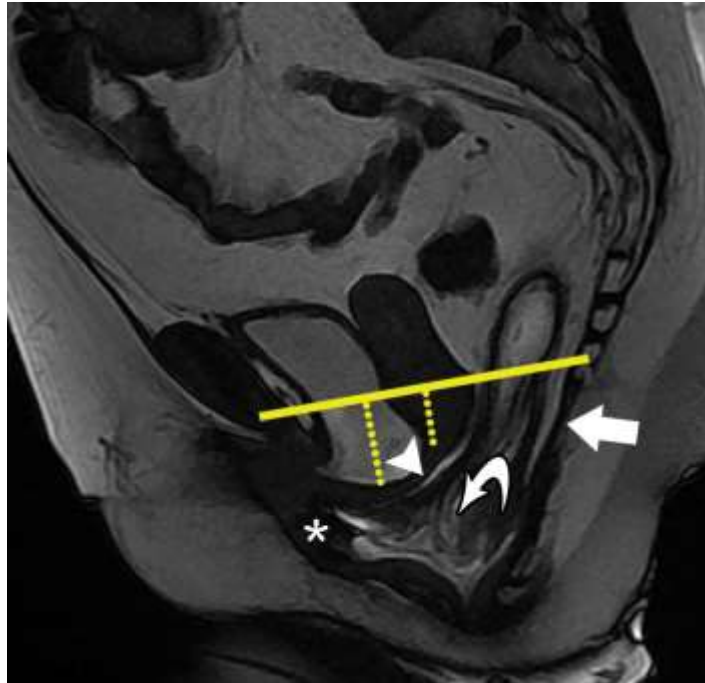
Rectal intussusception in a 48-year-old woman with suspected obstructed defecation. Midsagittal FIESTA MR image obtained during defecation shows intrarectal intussusception of the rectal wall (curved arrow). A large anterior rectocele (*) and pronounced caudal angulation of the levator plate (straight arrow) also are depicted. In the anterior and middle compartments, a moderate cystocele (long dotted line) and mild uterine prolapse (short dotted line) can be seen along with a peritoneocele (arrowhead), a lamella of mesenteric fat extending into the rectovaginal space alongside the upper third of the vagina. The detection of rectal intussusception in this patient altered surgical planning, resulting in the use of a transabdominal approach instead of a transperineal one and the addition of rectopexy to rectovaginal fascia repair.
